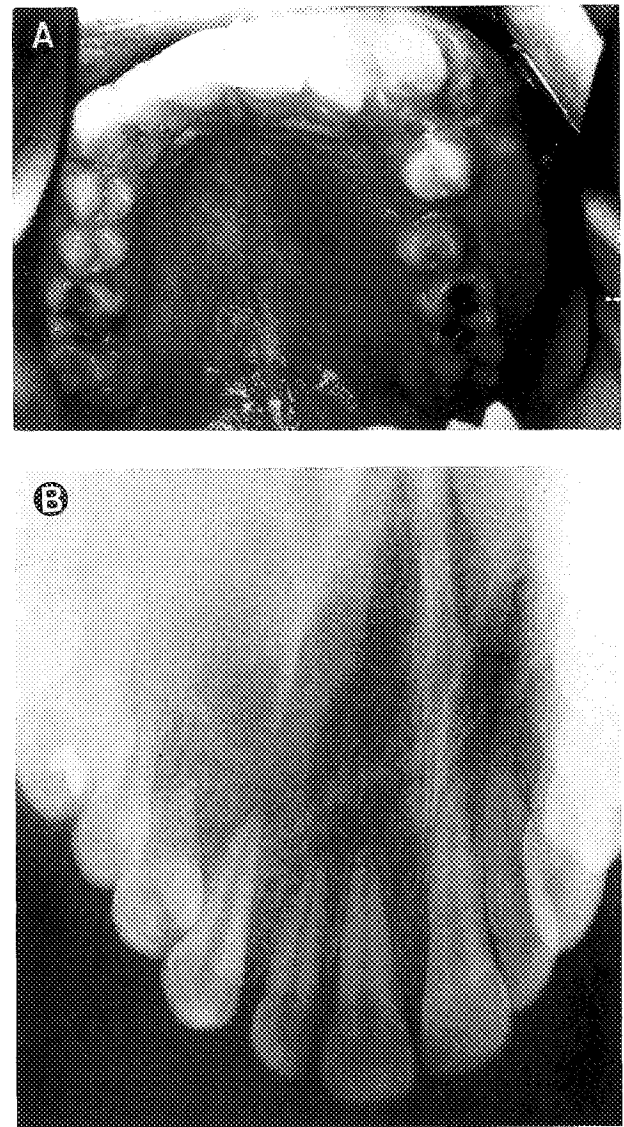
Craniofacial fibrous dysplasia. A, Intraoral view of lesion causing unilateral expansion of the maxilla in a white boy, age 11. B, Occlusal radiograph from a boy age 12 with fibrous dysplasia showing the ground-glass opacification and ill-defined margins. The clinical features in this patient were identical with those of the patient shown in A.
